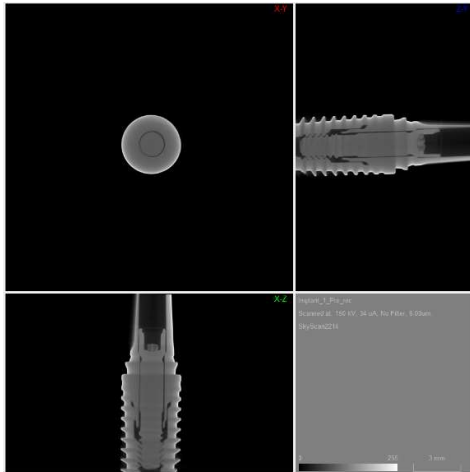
Pre Load Nano CT of Ti Implants and Abutments shows no Leakage
